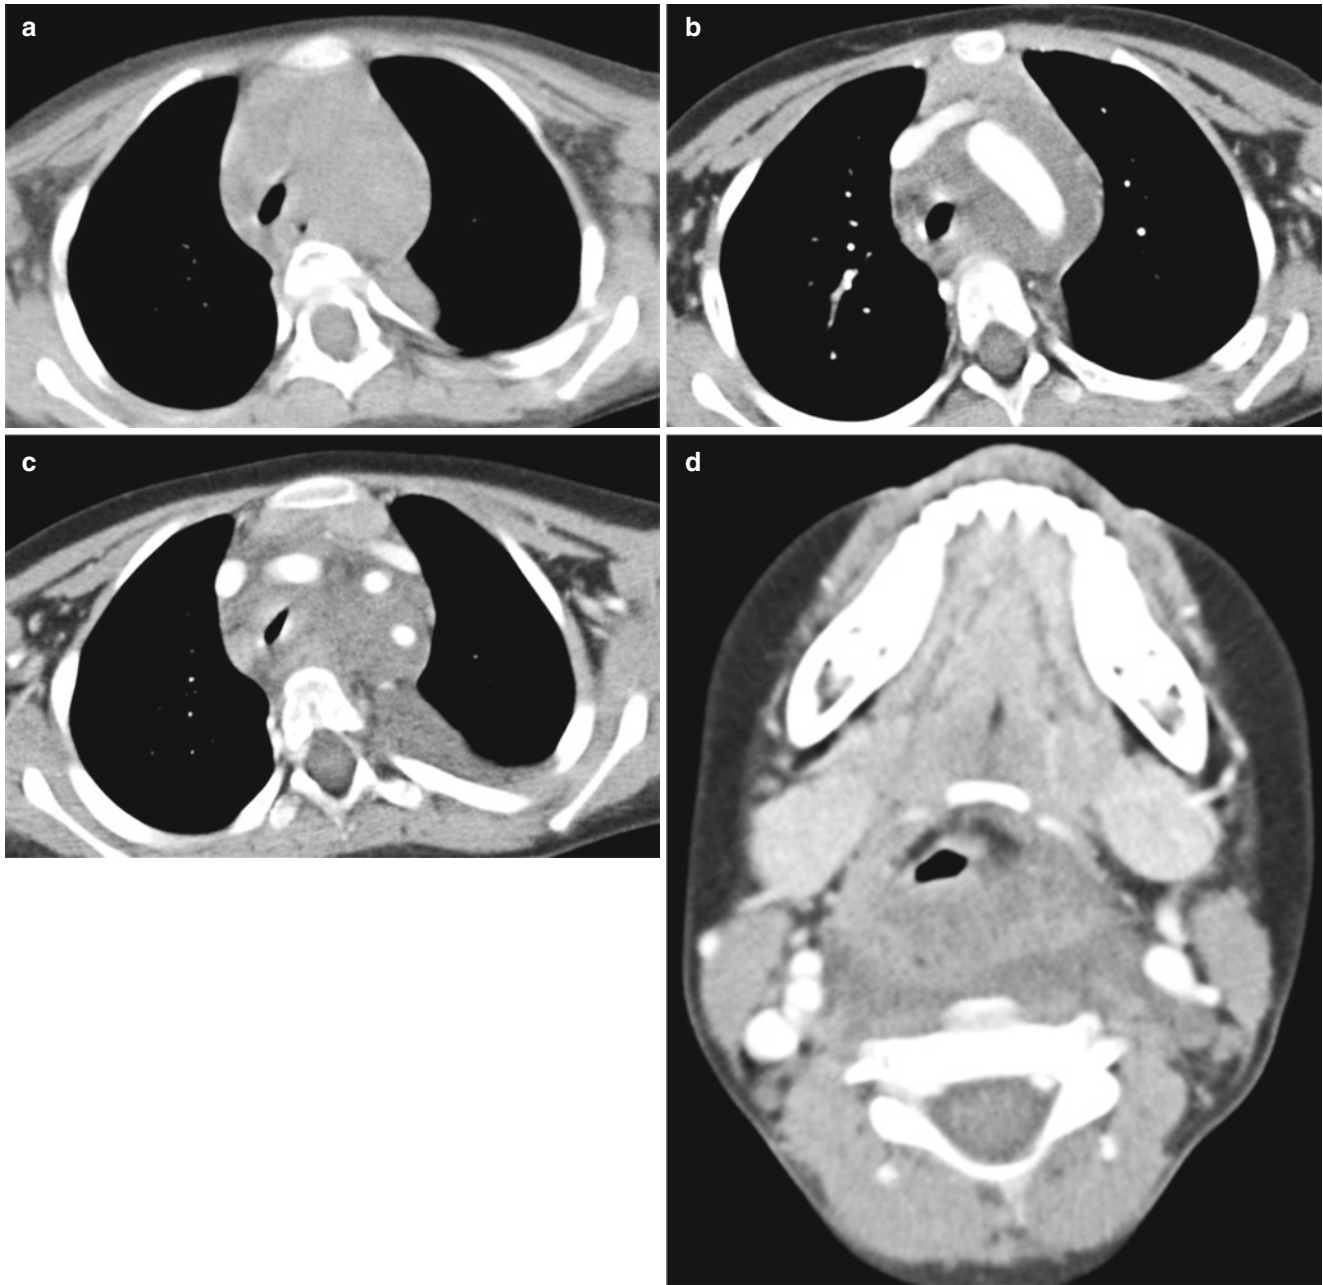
Lymphangiomas in a 5-year-old girl with dyspnea. (a–c) Nonenhanced (a) and contrast-enhanced (b, c) CT show a large low-attenuation mass in the middle mediastinal mass encasing the thoracic
